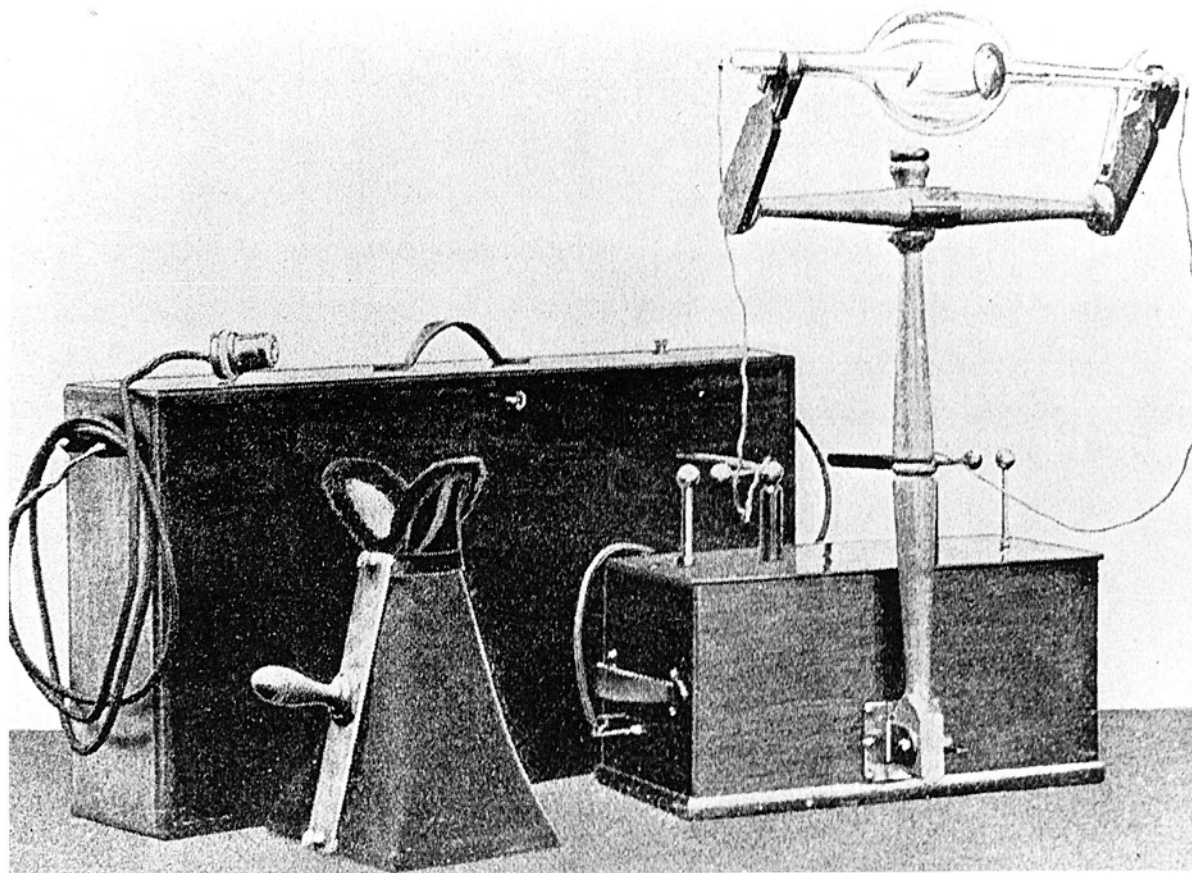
Early portable X-ray unit. The smaller box contains the coil; the larger, the electrolytic interrupter. The hand fluoroscope and open tube as generally used are shown.
